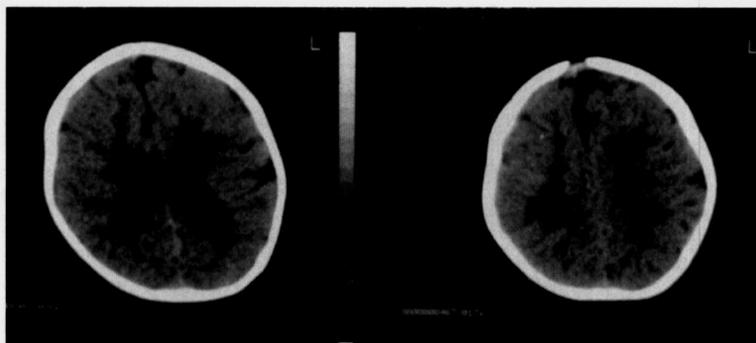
CT scan brain of patient 1 showing hypodensity of white matter in periventricular area indicating white matter demyelination
